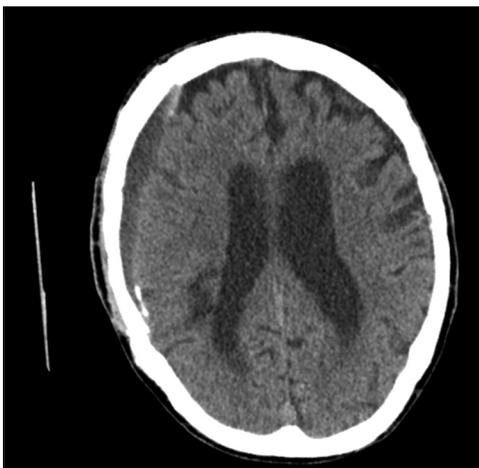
Axial noncontrast CT head 3 years prior to presentation showing right isodense extraaxial fluid collection within bounds of previous craniotomy (Unfortunately, we don't have any history as to why this scan was ordered. It was sent to use as part of the current workup for EDA)
